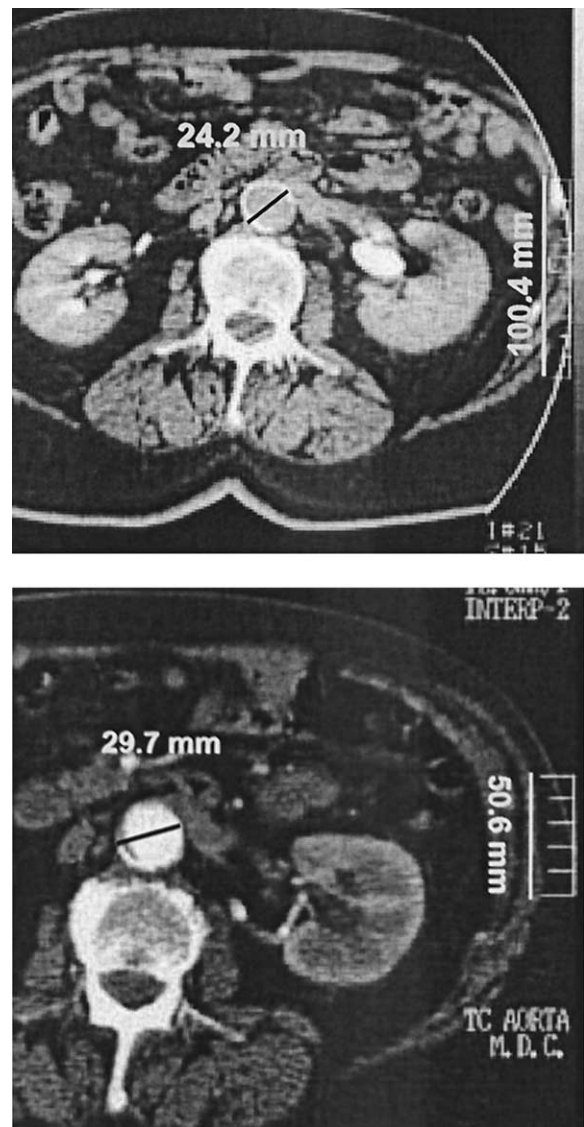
CT scans obtained at 1 month (*top*) and 24 months (*bottom*) after endograft placement show aortic neck dilatation of 24.2 and 29.7 mm.
